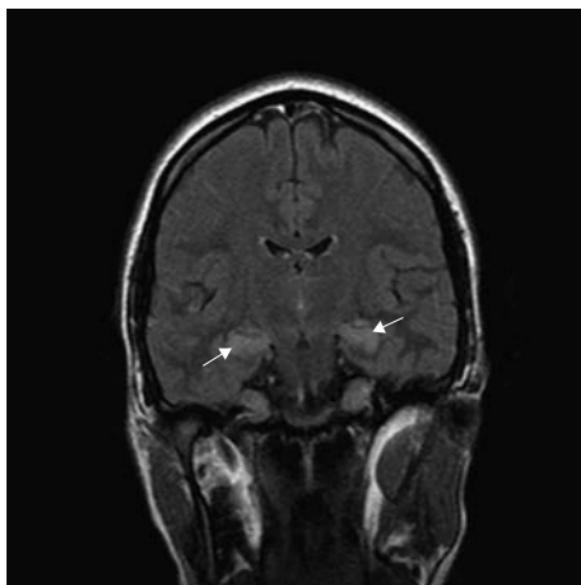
Limbic encephalitis (coronal FLAIR MRI). Symmetric hyperintensity and swelling of the hippocampus bilaterally (white arrows). While paraneoplasia is the most common aetiology, potassium channelopathies, status epilepticus, and hypoxic injury are other causes.
